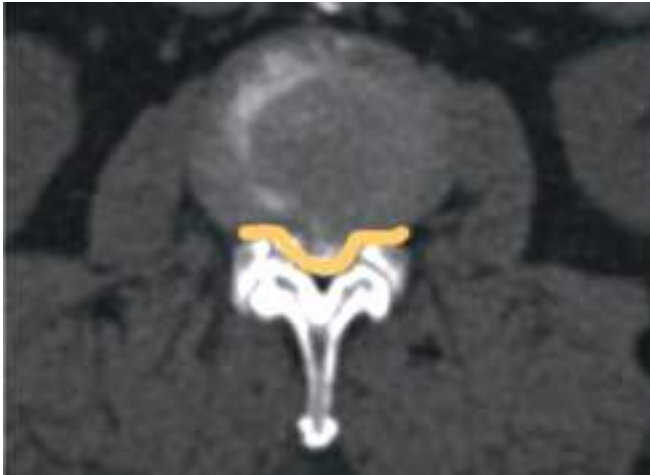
Disc protrusion in axial CT image
